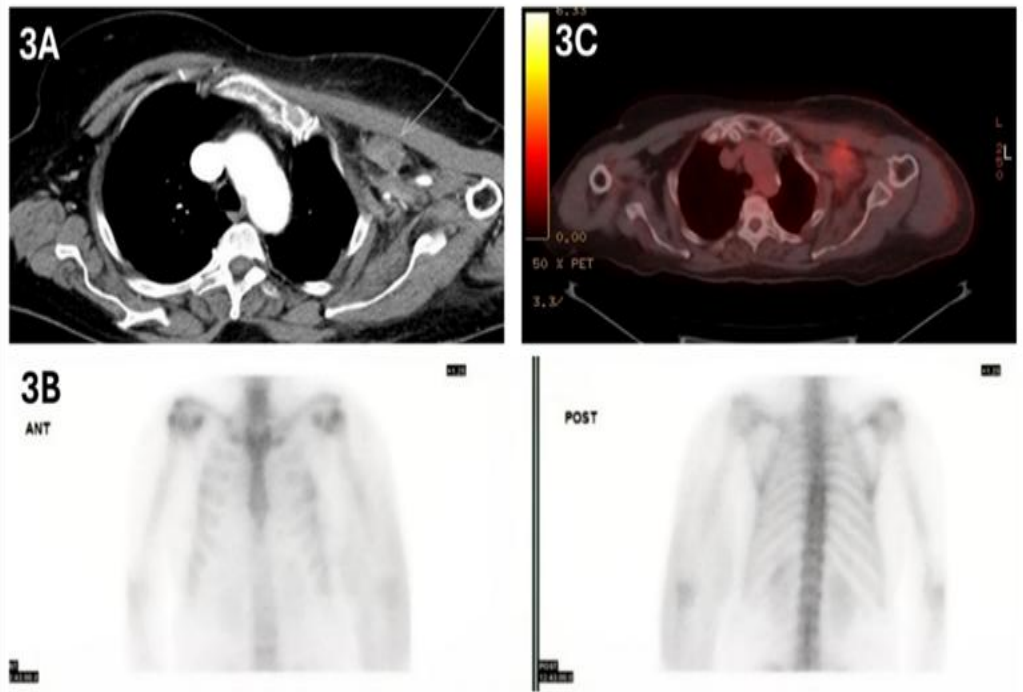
Contrast-enhanced CT of the neck and chest showing the left breast mass and an enlarged left supraclavicular lymph node. Figure 3B: 99mTc-MDP bone scan showing mildly increased radiotracer uptake in the left upper extremity consistent with lymphedema.
